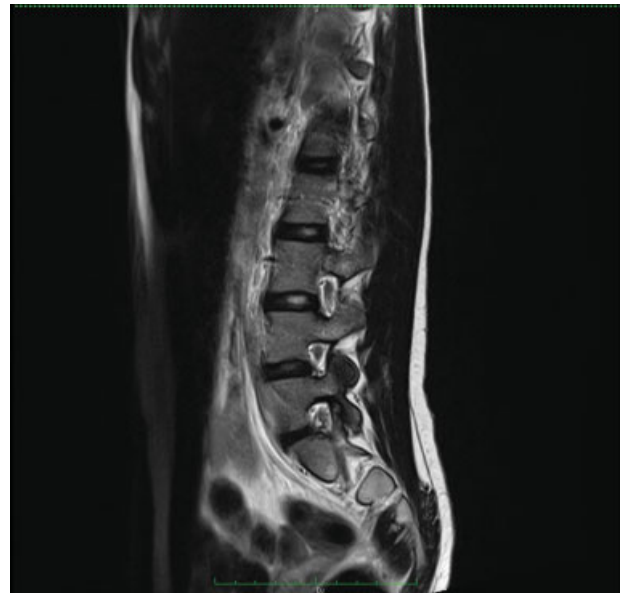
Lumbosacral spine contrast-enhanced T2-weighted magnetic resonance imaging (A) showing the lesion's total excision.
